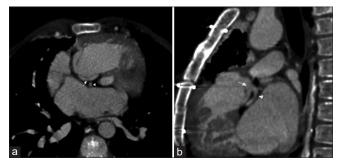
Right coronary artery. (a) axial and (b) sagittal computed tomography pulmonary angiogram images showing the right coronary artery (arrowhead) arising from the left coronary cusp (arrow)
